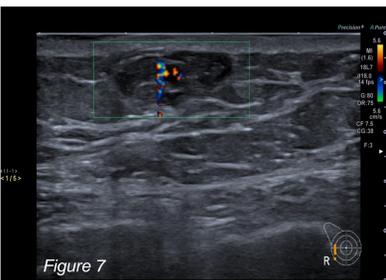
Ultrasound of symptomatic area shows indeterminate area of mixed echogenicity and internal colour doppler flow.
